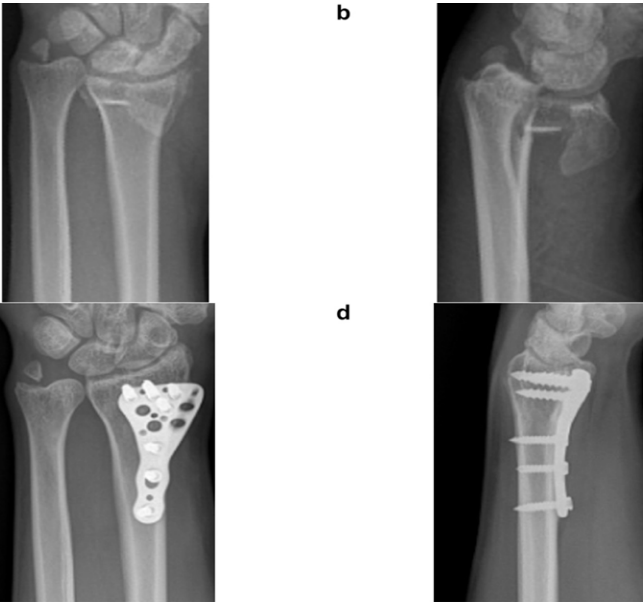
Preoperative (left) and postoperative (right) anteroposterior and lateral wrist radiographs of a 59-year-old female patient (Frykman type 4, AO type B2). (a) Preoperative anteroposterior radiograph showing intra-articular and dorsally angulated distal radius fracture. (b) Preoperative lateral radiograph demonstrating dorsal displacement and cortical comminution. (c) Postoperative AP radiograph after volar locking plate fixation, showing restoration of radial height and articular congruency. (d) Postoperative lateral view demonstrating correction of dorsal angulation and stable fixation with subchondral support
